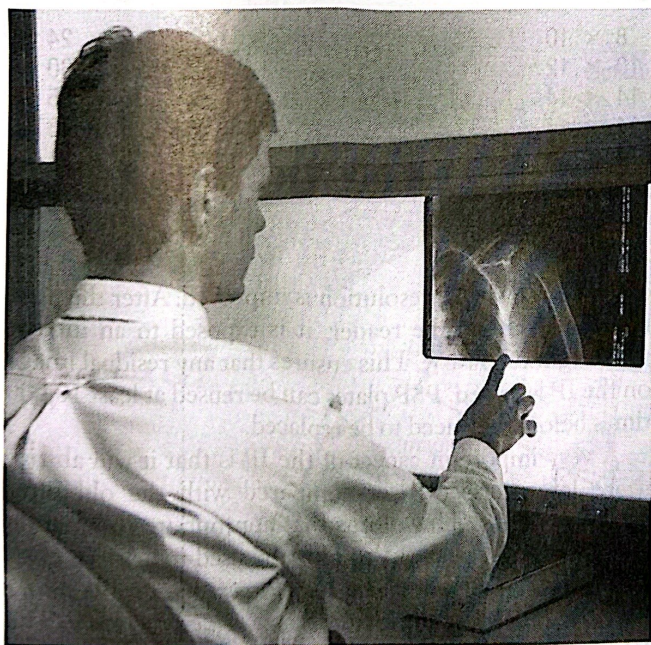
A radiologist interpreting a shoulder x-ray image on a sheet of film using an illuminator in conventional radiology.
